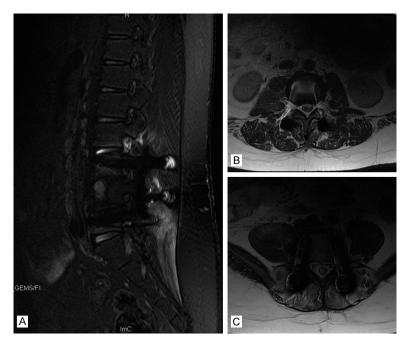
The lumbar MRI showed an abnormal signal in the vertebral body of L4.
